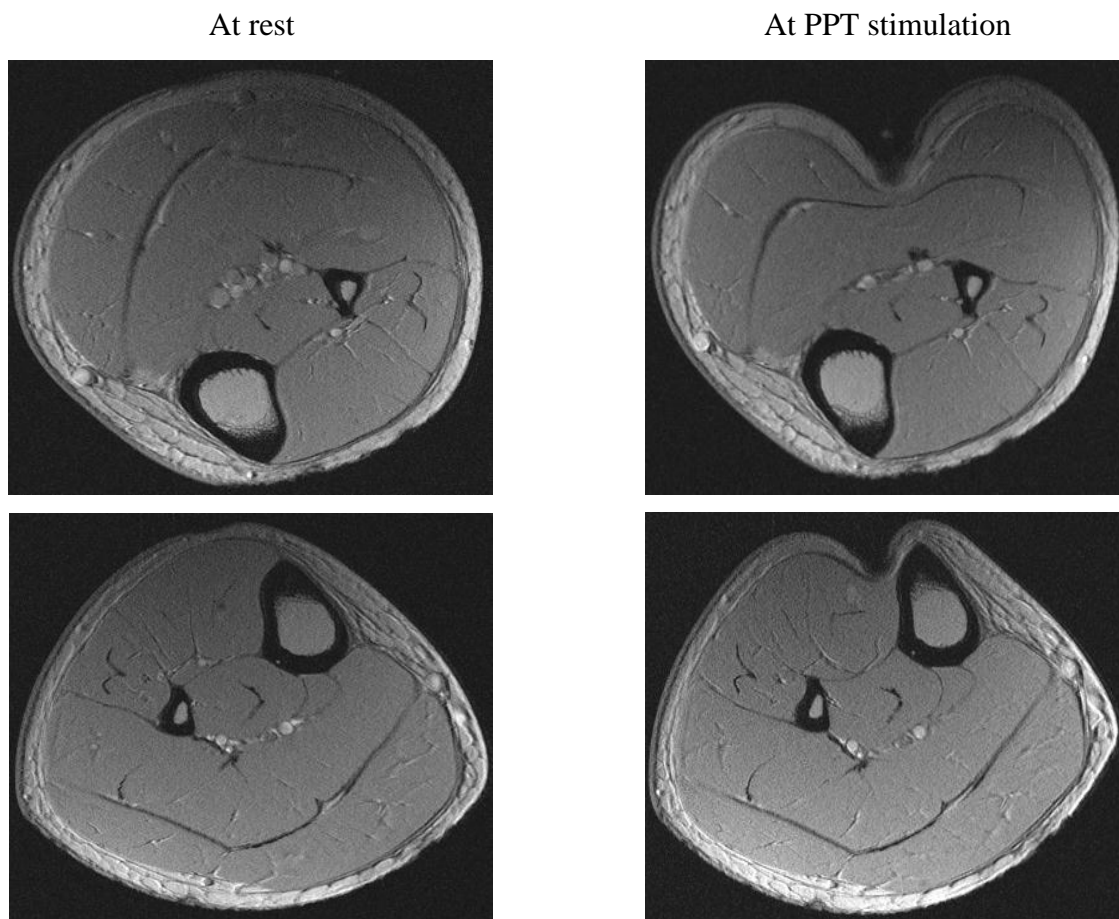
Magnetic resonance image (1.5 T, 28 mm) during pressure pain assessment using a specifically developed hydraulic pressure algometer. The images are recorded from a male subject at rest (left) and pressure pain threshold (right). On the first line, the pressure pain is assessed on the gastrocnemius muscle, while on the second line on tibialis anterior muscle. The PPT on tibialis anterior muscle was 338 kPa, while on gastrocnemius muscle was 401 kPa. Unpublished data.
